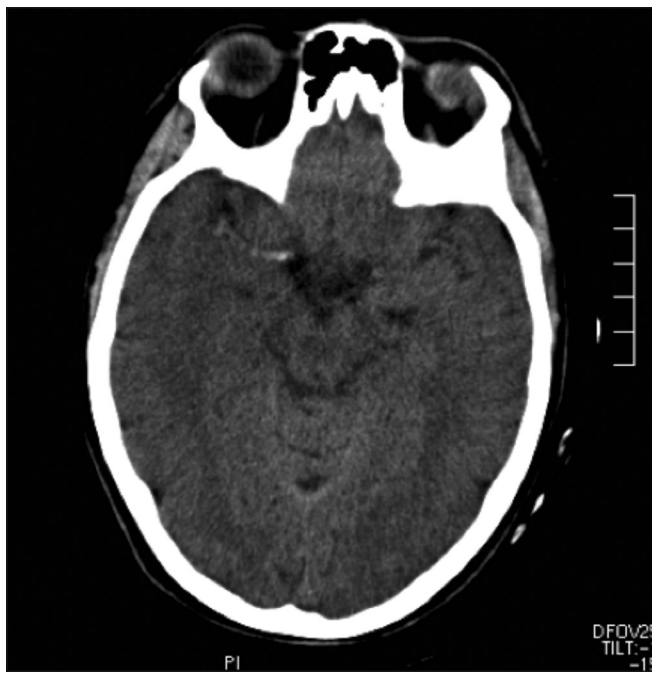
CT of the head, showing hyper-dense right middle cerebral artery.
